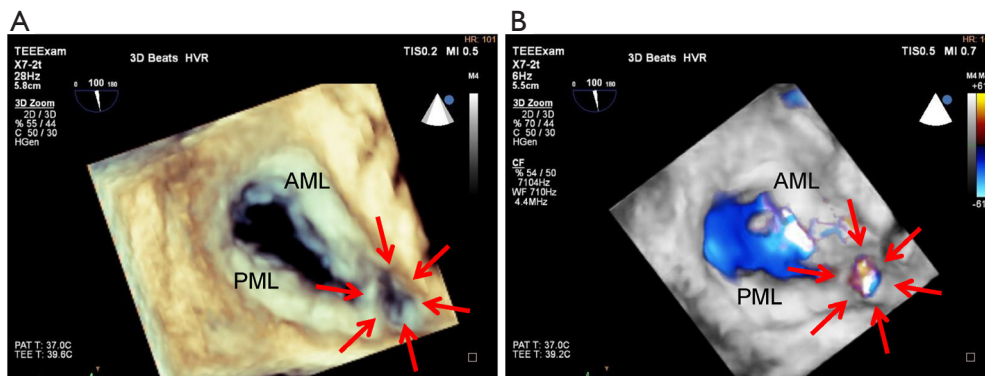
Acute mitral regurgitation due to mitral leaflet perforation. Acute mitral regurgitation due to mitral leaflet perforation close to the posterior commissure (red arrows) occurred after transcatheter heart valve (THV) deployment because the THV might be placed with wire entanglement in the mitral apparatus. (A) 3D imaging; (B) 3D color Doppler imaging. AML, anterior mitral leaflet; PML, posterior mitral leaflet.
